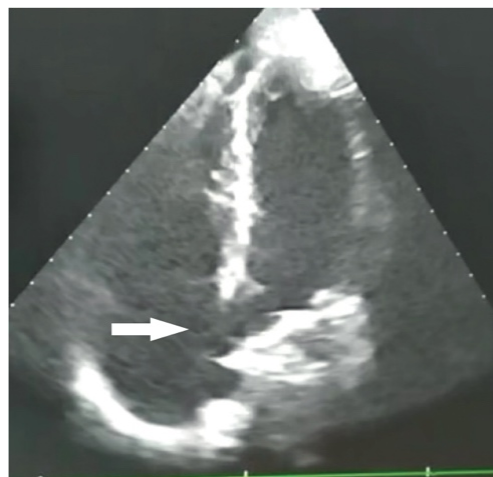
Transesophageal echocardiography, four-chamber position. The white arrow indicates the left ventricular-right atrial communication
